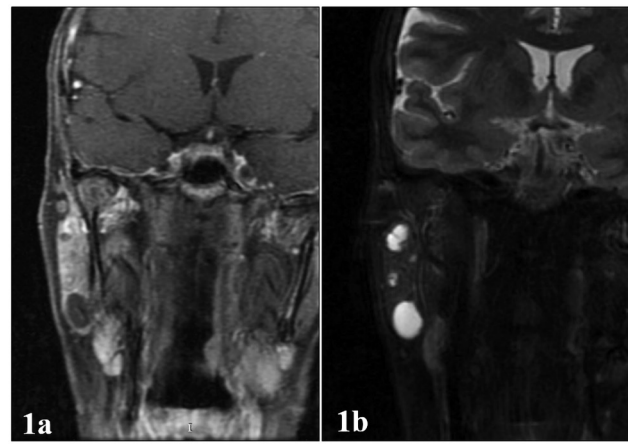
Magnetic resonance (MR) imaging. (a) T1-weighted MR showing multiple nodules in the left parotid; (b) the same nodules appearing as cystic in T2-weighted MR images.
